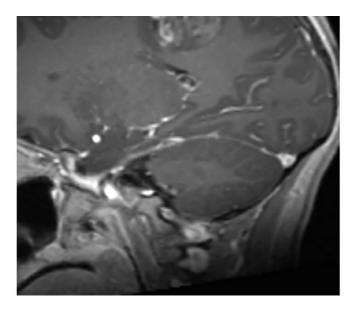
The medial left frontoparietal complex-appearing anaplastic astrocytoma in this patient demonstrates low T1 signal intensity (top left) and FLAIR hyperintensity (top right) with a mixed-signal hemorrhagic component at its posterolateral aspect. Black signal on the susceptibility-weighted imaging (middle left) also reflect this hemorrhage. The tumor also has a heterogeneous enhancement pattern (middle right, coronal; bottom row, sagittal) that is more typical of higher-grade adult primary brain tumors than of grade II tumors.
